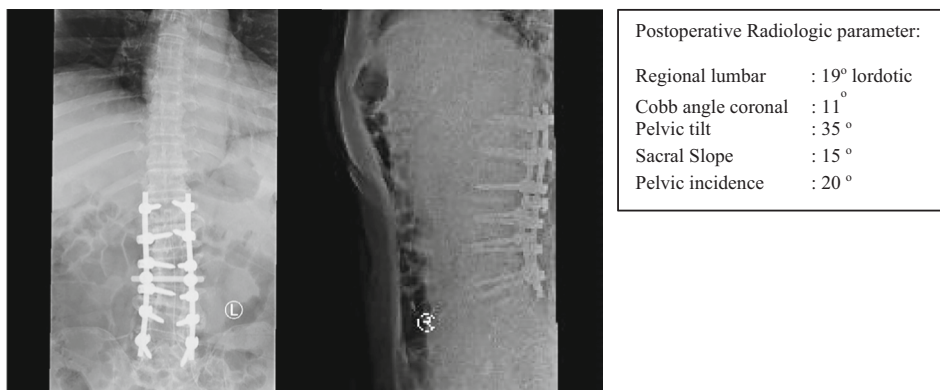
Case 3 postoperative radiograph.
